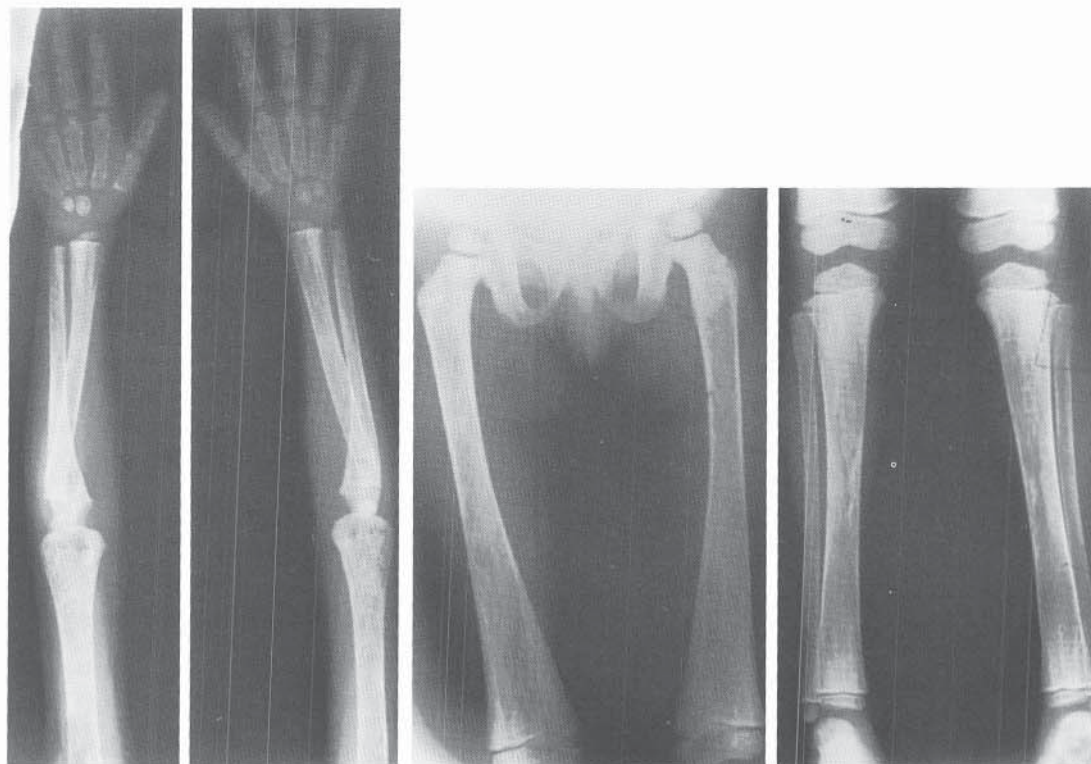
Osteopathia striata. AP radiographs of upper and lower limbs show the striations parallel to the longitudinal axis. They are especially marked in the metaphyseal areas.
